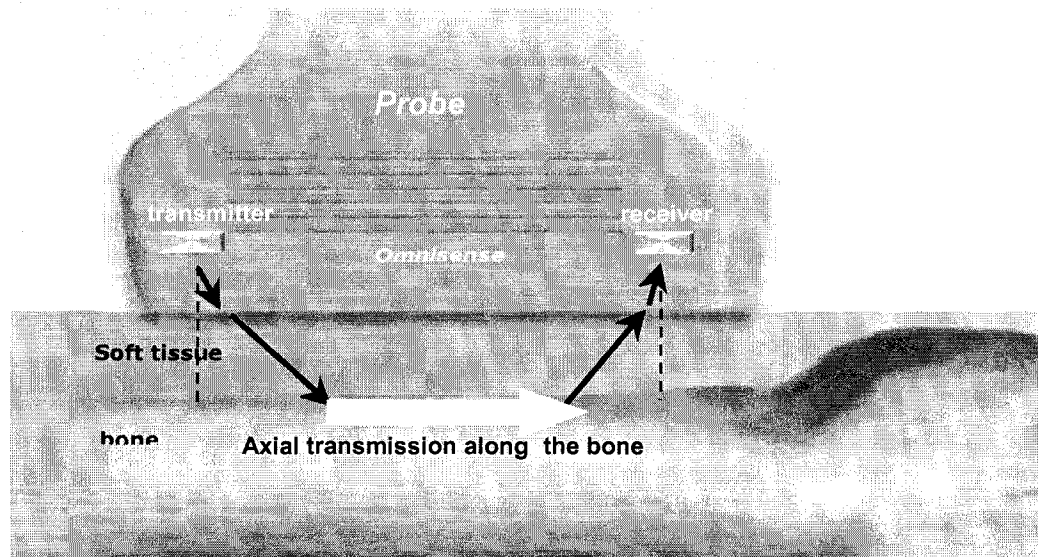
Omnisense Ultrasonometer Technology
